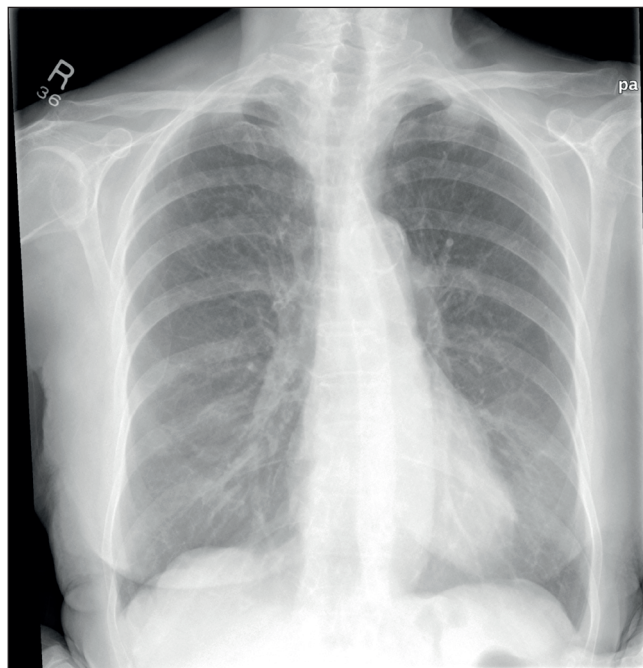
left Apical Tumour, chest radiograph
